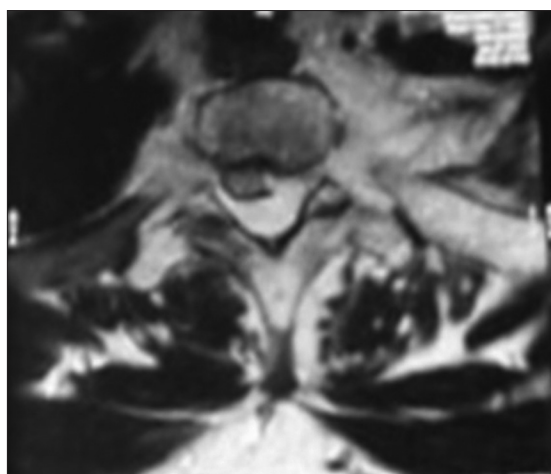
MRI dorsal spine axial view T2W image showing contiguous infiltration into left costovertebral joint and adjacent rib with evident altered bone marrow signal. Infiltrative extradural/epidural lesion causing significant mass effect on spinal cord and shift of cord to right side depicted.
